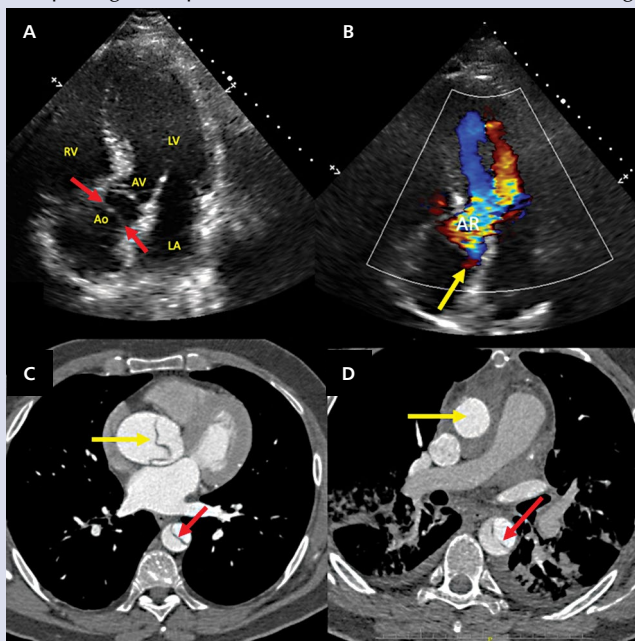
A. Apical five-chamber view showing suspected intimal flap (red arrows) very close to the aortic valve (AV, white arrow); LV — left ventricle; RV — right ventricle; LA — left atrium; Ao — aortic root; B. Corresponding five-chamber image in colour Doppler mode: perforation of the intimal flap (yellow arrow). LV outflow tract is totally filled by the severe aortic regurgitation jet (AR); C. Urgent computed tomography (CT) scan documenting dissection of the ascending and descending aorta (yellow and red arrows, respectively); D. Post-surgery CT scan showing normal ascending aortic prosthesis (yellow arrow) and residual dissection of the descending aorta (red arrow). Of note, before the surgery both false and true lumina of the descending aorta are equally filled with contrast, and the true lumen (red arrow) is smaller compared to the false lumen (C). Post-surgery the contrast is predominantly present in true lumen (red arrow; D). True lumen post-surgery is larger than the false lumen
